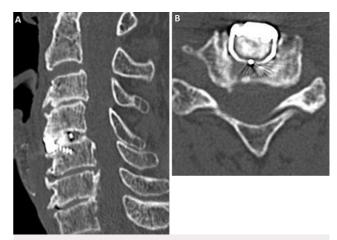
One-year postsurgical computed tomography (CT) showing bony union at C4–5. A: Coronal CT. B: Axial CT showing the disappearance of the intraforaminal gas.
